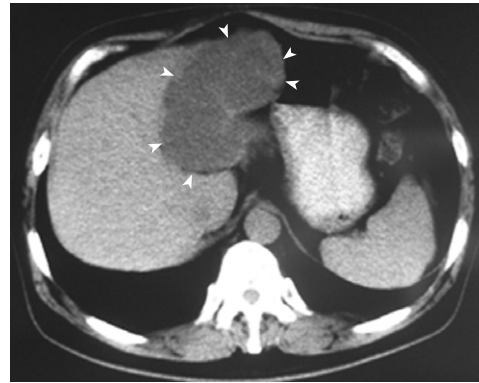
Biliary cystadenocarcinoma. Computed tomography shows a huge cystic tumor (arrowheads) in the left liver lobe, with no clear septations and solid components.
